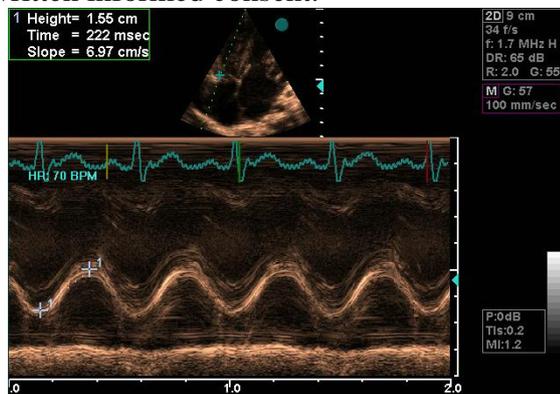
Tricuspid annular plane systolic excursion (TAPSE) in the lateral apical 4-chamber view by M-mode.
